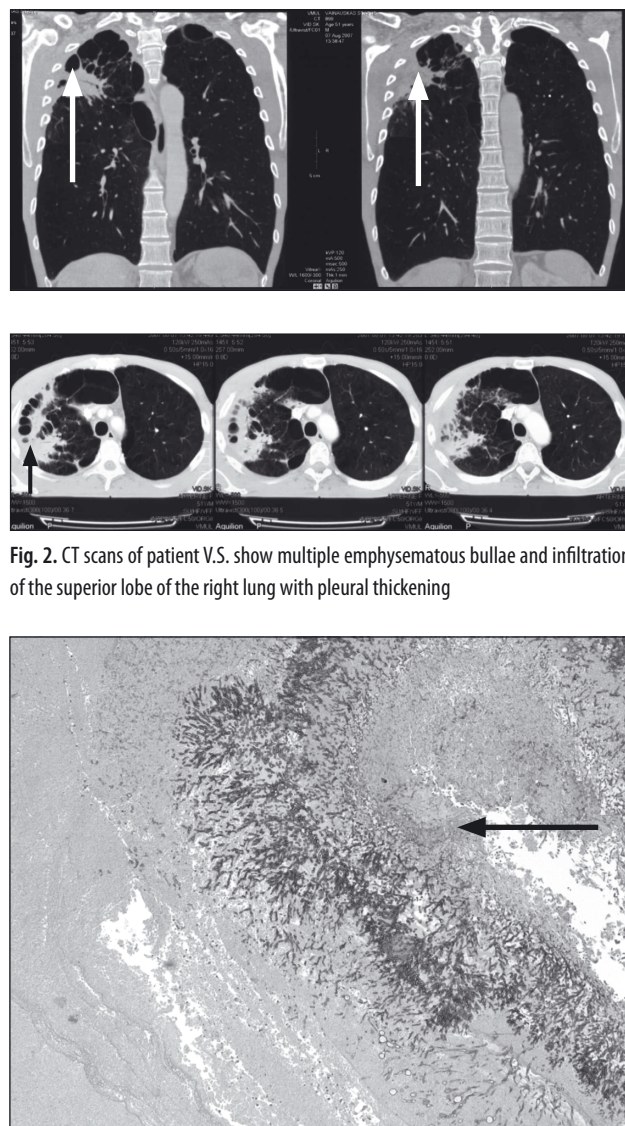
CT scans of patient V.S. show multiple emphysematous bullae and infiltration of the superior lobe of the right lung with pleural thickening
